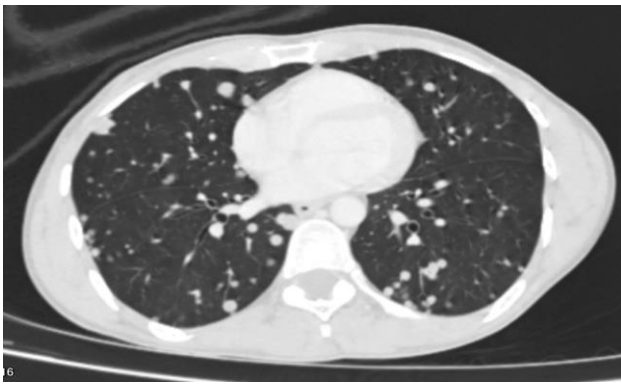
Contrast-enhanced CT of the chest showing multiple pulmonary nodules.
